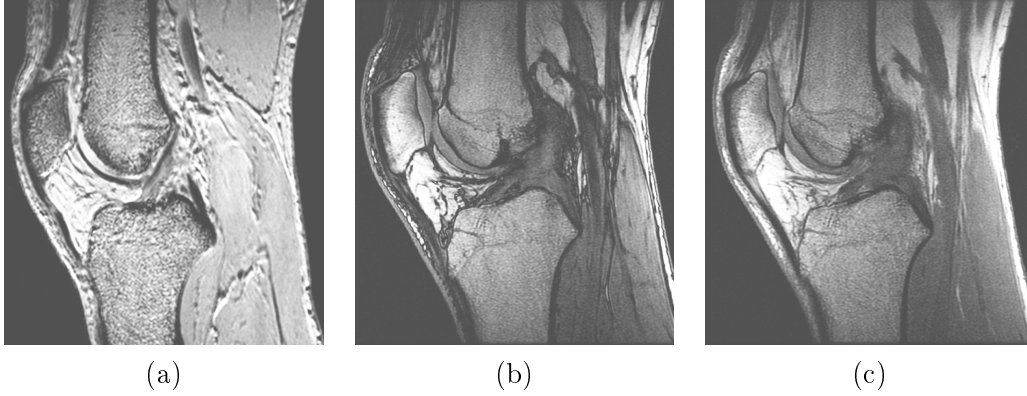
Some MR images of the knee: (a) High resolution T_1 FLAIR Saggital, (b) T_1 FSPGR Saggital, and (c) its echo signal. FLAIR stands for Fluid Attenuated Inversion Recovery and FSPGR for Fast Spoiled Gradient-Recalled-Echo.
